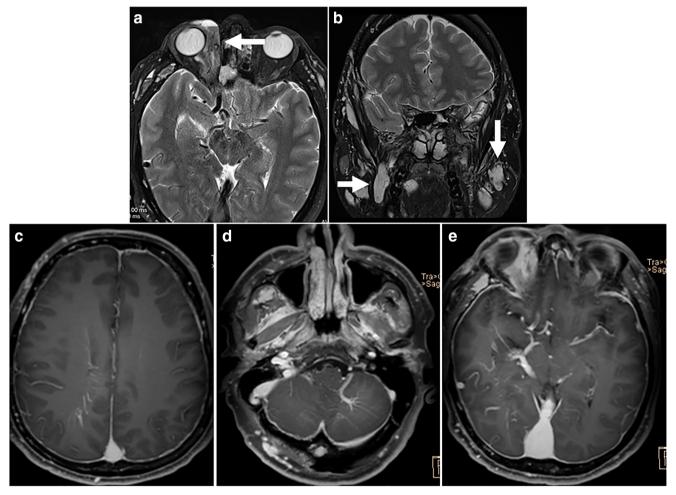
Cerebral venous metameric syndrome (CVMS) types 2 and 3. A patient with multiple orbito-facial venous vascular anomalies in a pattern consistent with CVMS types 2 and 3. T2-weighted images demonstrating multiple a orbital (*arrow*) and b facial venous malformations (*arrows*). c
